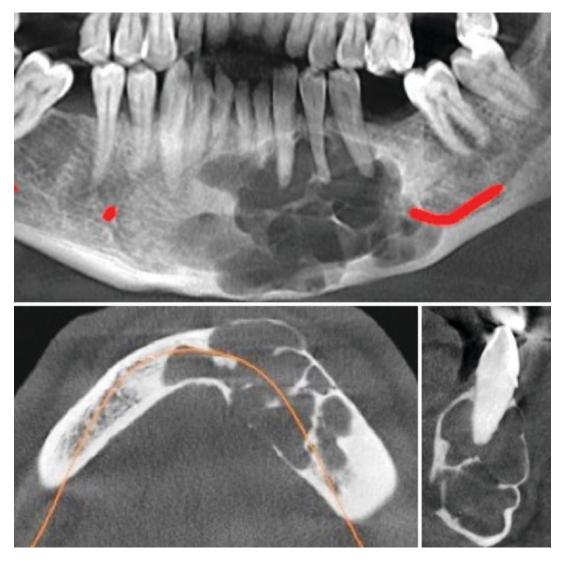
Glandular Odontogenic Cyst. A: CBCT panoramic reconstruction image reveals a multilocular hypodense lesion which is in relation to the roots of mandibular anterior teeth. B: CBCT axial slice reveals a multilocular hypodense lesion with buccal and lingual cortical plate expansions at mandibular anterior region. C: CBCT cross-sectional image reveals expansion and thinning at buccal and lingual cortical plates without any appearance of lamina dura and periodontal ligament space. The associated tooth has the "floating-teeth" appearance even though Glandular Odontogenic Cyst is a benign lesion
